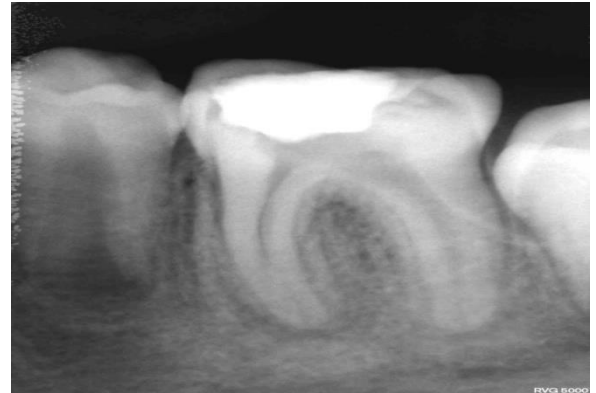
Radiograph at 12 months showing continued root development with apical constriction.
